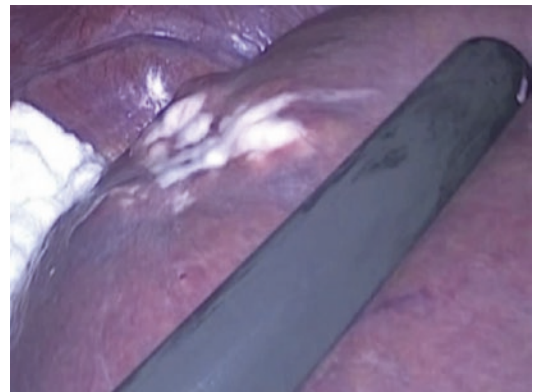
Delimitation of surgical margin with laparoscopic ultrasound in a non-anatomic liver resection
